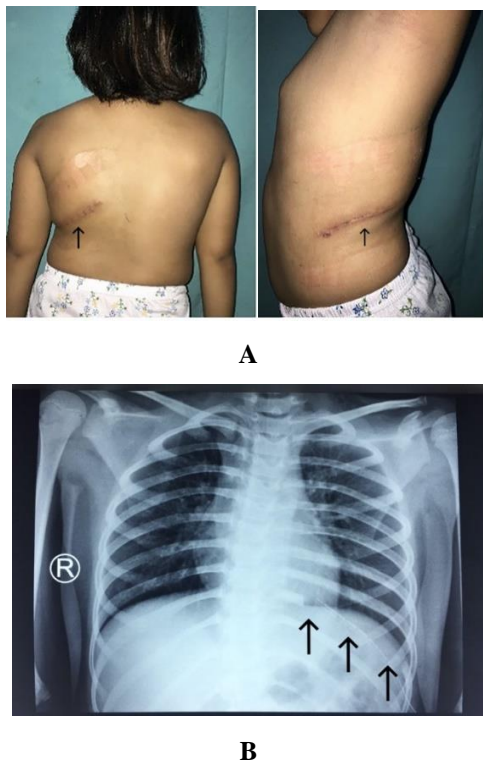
Post-operative clinical (A), Post-operative thorax x-ray PA (B)
